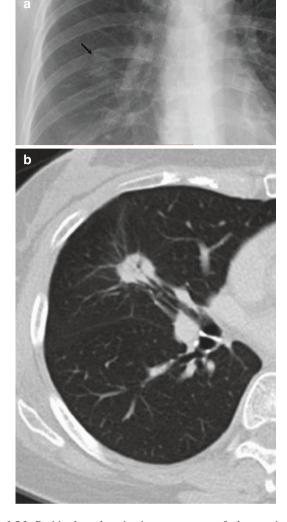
Positive bronchus sign in a proven case of adenocarcinoma. (a) Frontal radiograph shows an ill-defined nodule with air bronchograms. (b) Axial CT image shows a nodule with dilated bronchi leading to it
